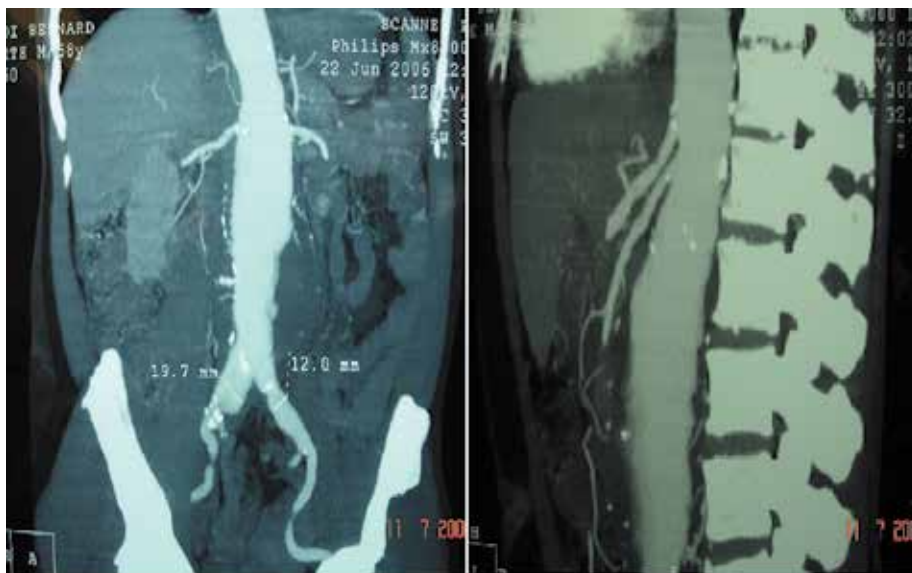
CT angiography of a type IV thoracoabdominal aneurysm
